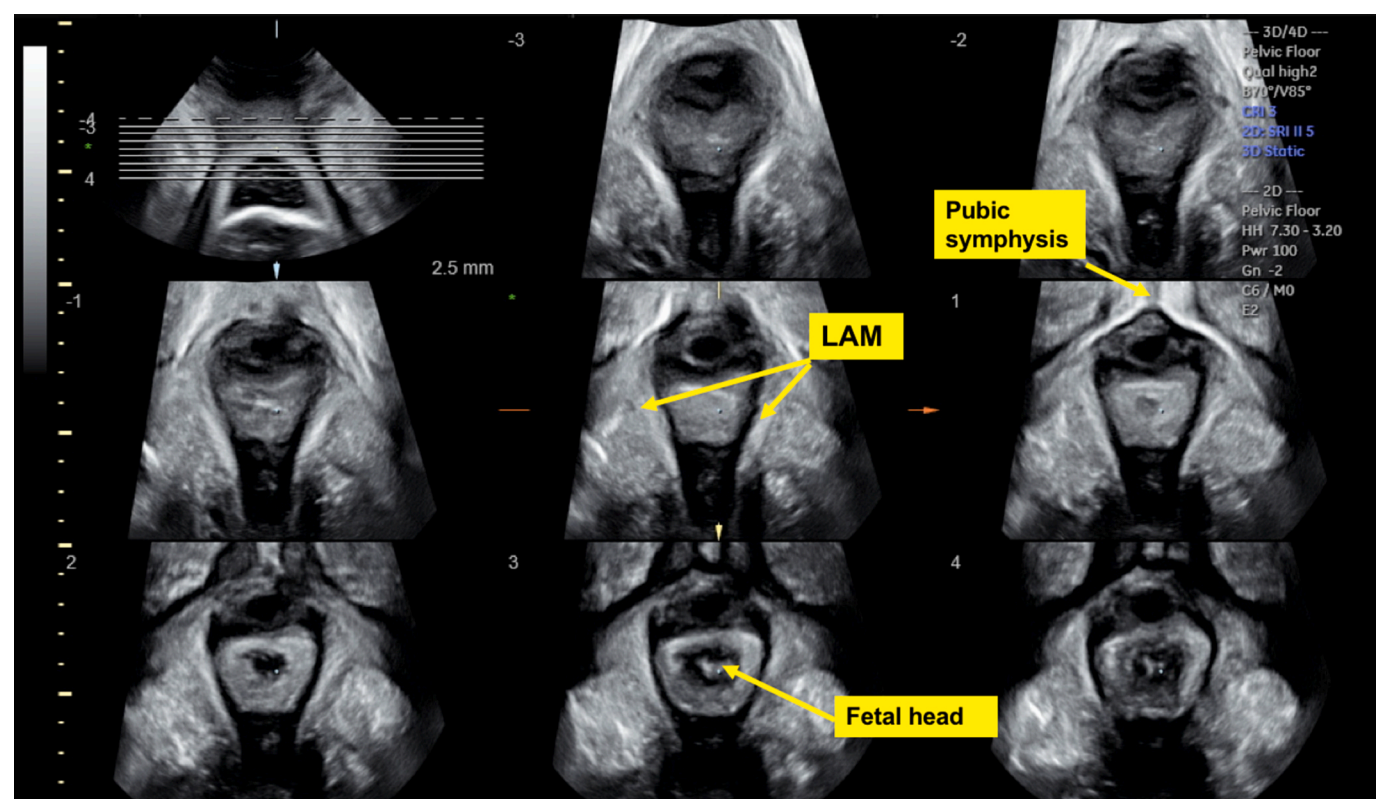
Tomographic ultrasound imaging: intact levator ani muscle during second stage of labour.
